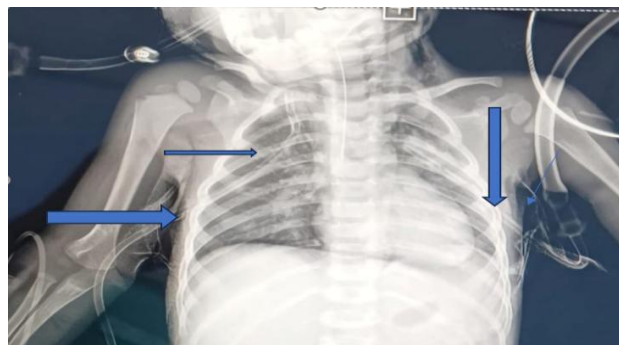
Chest radiograph showing right sided pneumothorax. Anteroposterior chest radiograph demonstrating right sided pneumothorax (arrow), right intercostal drain and right sided bronchopneumonia with tracheostomy tube.
